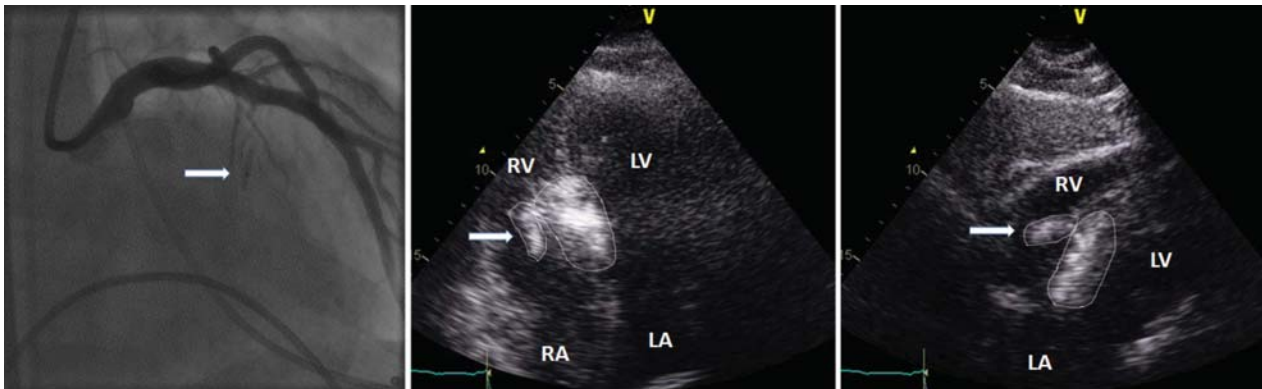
Alcohol septal ablation in the patient shown in (Fig. 1). Left, an over-the-wire balloon (arrow) is inflated in the dominant septal branch (number 1 in Fig. 1). Transthoracic myocardial contrast echocardiography in the apical 4-chamber (middle) and subcostal (right) views is shown after injection of Gelafundin® (BBraun, Melsungen, Germany) in the target septal branch. There is good demarcation of the basal septum (i.e. the target area for ablation) but also clear opacification of the right ventricular papillary muscle (arrow, both areas demarcated with a dotted line). LV: left ventricle, RV: right ventricle, LA: left atrium, RA: right atrium.
